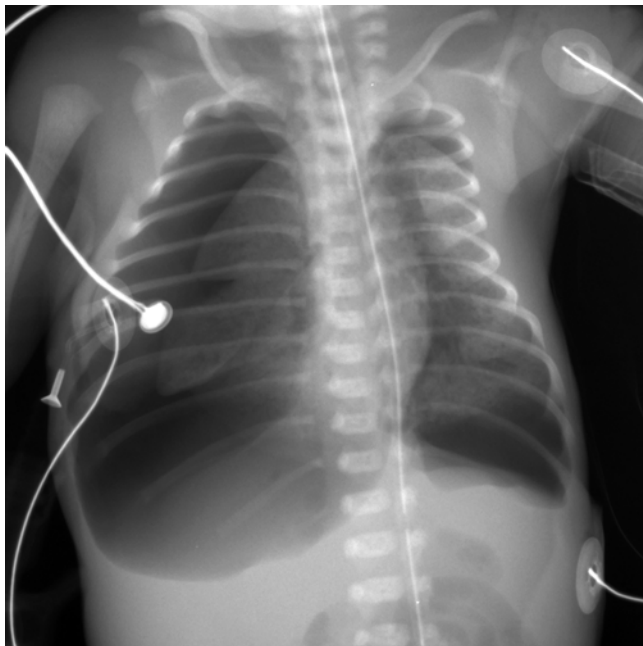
Bilateral tension pneumothorax in a pre-term infant with hyaline membrane disease. Frontal radiograph shows large pleural air collections bilaterally. Chest cavity expansion, inversion of the diaphragms, and narrow mediastinal shadow indicate high pressure in the air-filled pleural spaces
